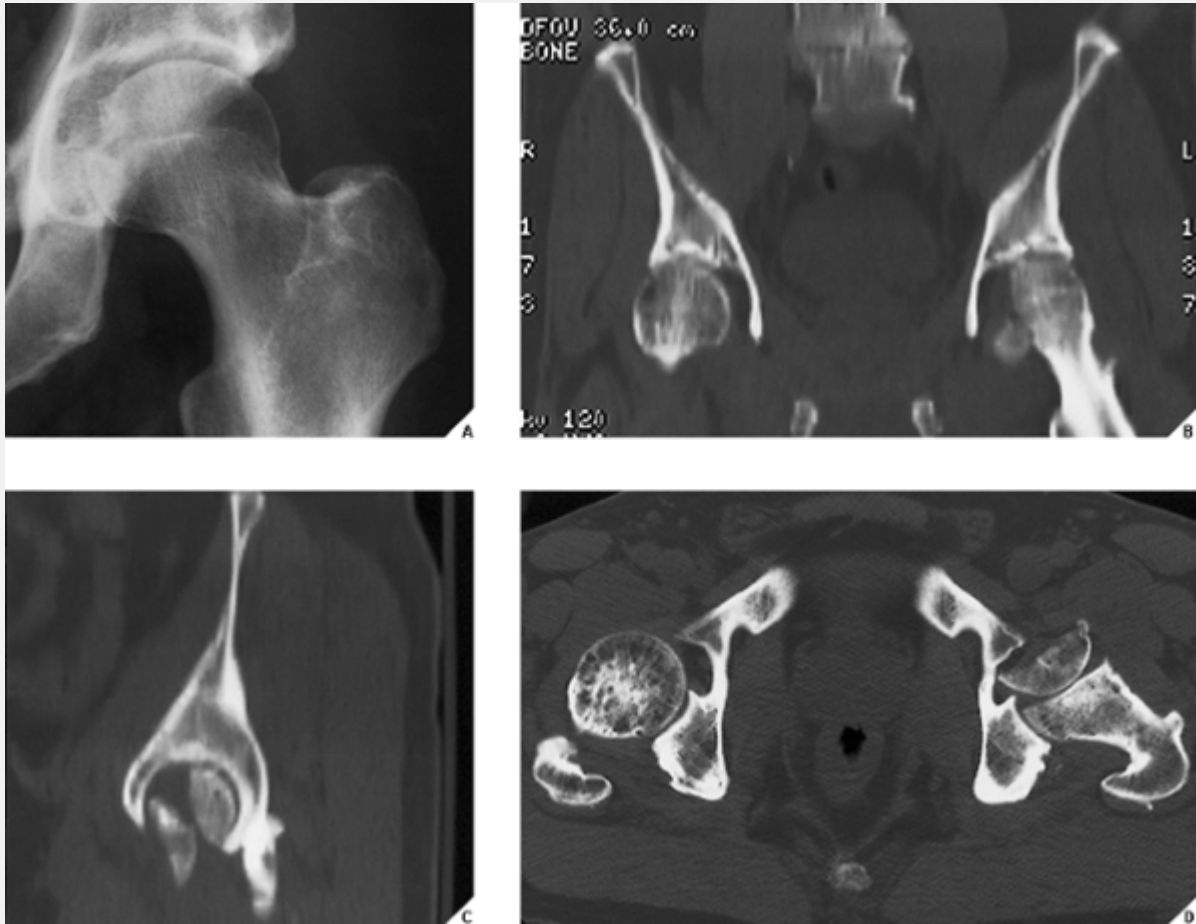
CT multiplanar imaging. A 62-year-old man sustained a posterior dislocation of the left femoral head. After reduction of dislocation, the anteroposterior radiograph of the left hip showed increased medial joint space and distortion of the medial aspect of the femoral head (A). To evaluate the hip joint further, CT was performed. Coronal (B) and sagittal (C) reformatted images showed unsuspected fracture of the femoral head, and axial image (D) demonstrated a 180-degree rotation of the fractured fragment.
